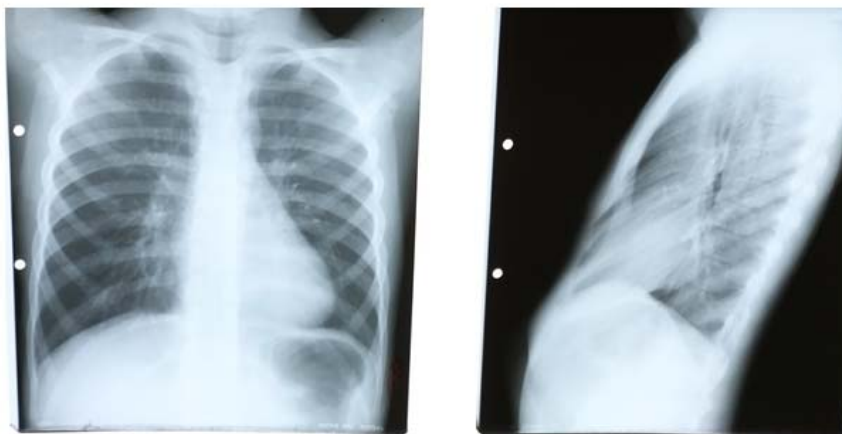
Chest x-ray (posteroanterior, lateral) of the presented case
